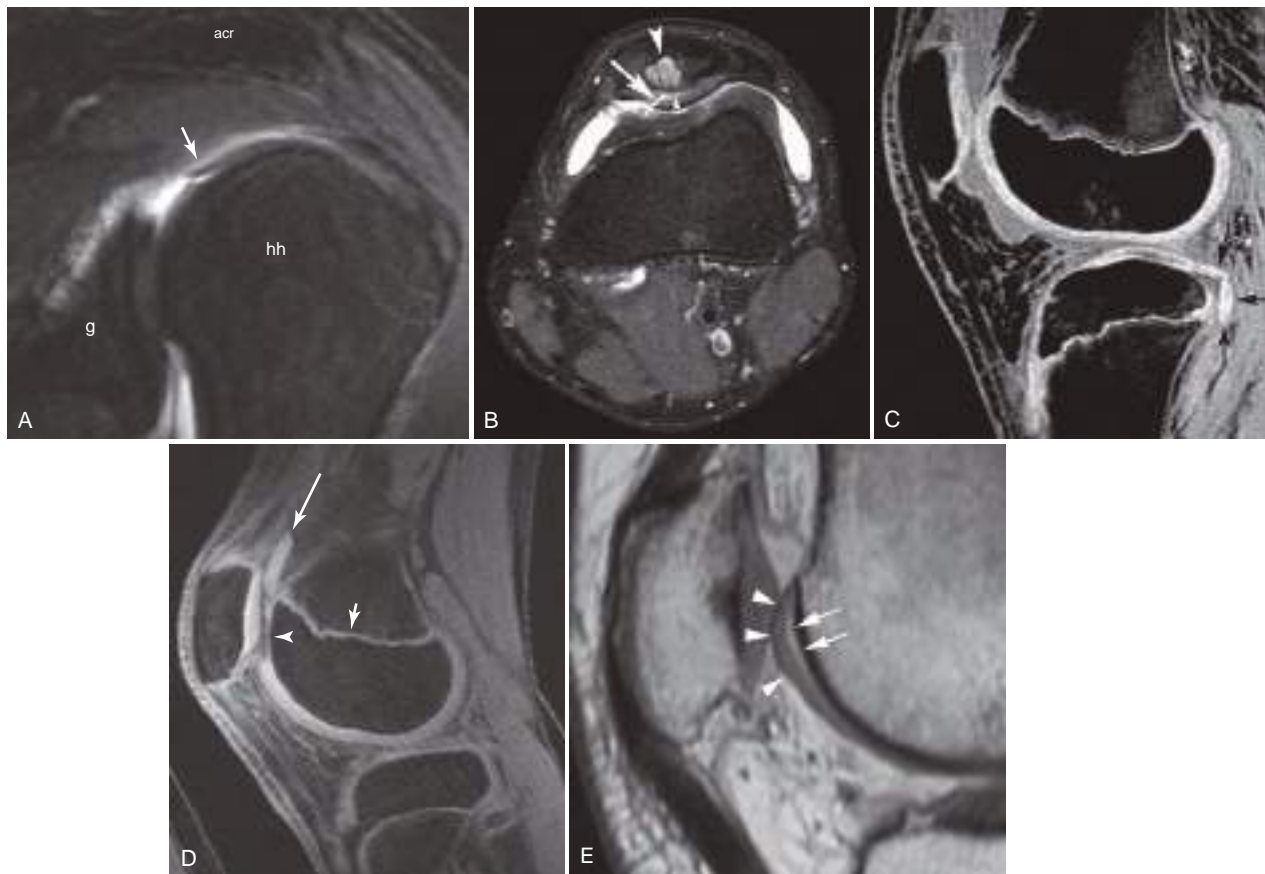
Articular cartilage defects: flap tears and delamination. (A) Small humeral head flap tear. Oblique sagittal fat-suppressed T2-weighted fast spin-echo MR image shows flap tear (*arrow*) outlined by high-signal joint fluid. (B) Fissure with flap tear and partial delamination. Axial fat-suppressed fast spin-echo T2-weighted MR image (echo time, 60 msec) of a painful left knee shows an oblique fissure in the medial patellar facet (*arrow*) that extends laterally (*small arrowhead*). Also note the adjacent patellar subchondral cyst (*large arrowhead*). (C) Delamination of posterior lateral tibial plateau (*arrows*). Sagittal fat-suppressed spoiled gradient-echo (SPGR) MR image in an adolescent who also sustained an anterior cruciate ligament tear with this injury. (D) Displaced full-thickness cartilage fragment. Fat-suppressed three-dimensional SPGR sequence. Recall that cartilage is bright on this sequence. Note the femoral trochlea chondral defect (*arrowhead*) and superiorly displaced fragment (*long arrow*). Also note that the physis (growth plate) has similar bright signal, a normal finding (*short arrow*). (E) Subtle delamination. Femoral trochlea cartilage (*arrowheads*) is separated from subchondral bone (*dark stripe*) by a thin layer of bright fluid signal (*arrows*). *acr*, Acromion process; *g*, glenoid; *hh*, humeral head.
